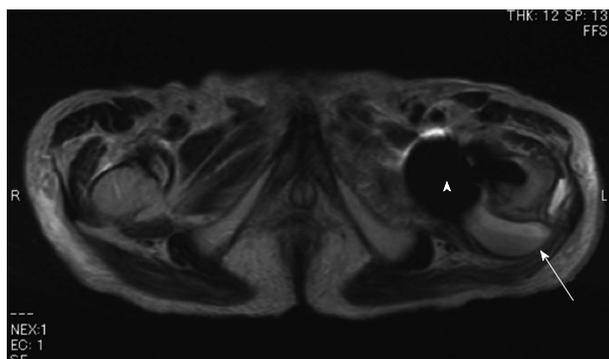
A 93-year-old male with an infection after hemiarthroplasty for the left femoral neck fracture. Axial T2-weighted image reveals a cystic lesion with a fluid-fluid level (arrow) adjacent to the posterior aspect of the endoprosthesis (arrowhead).
